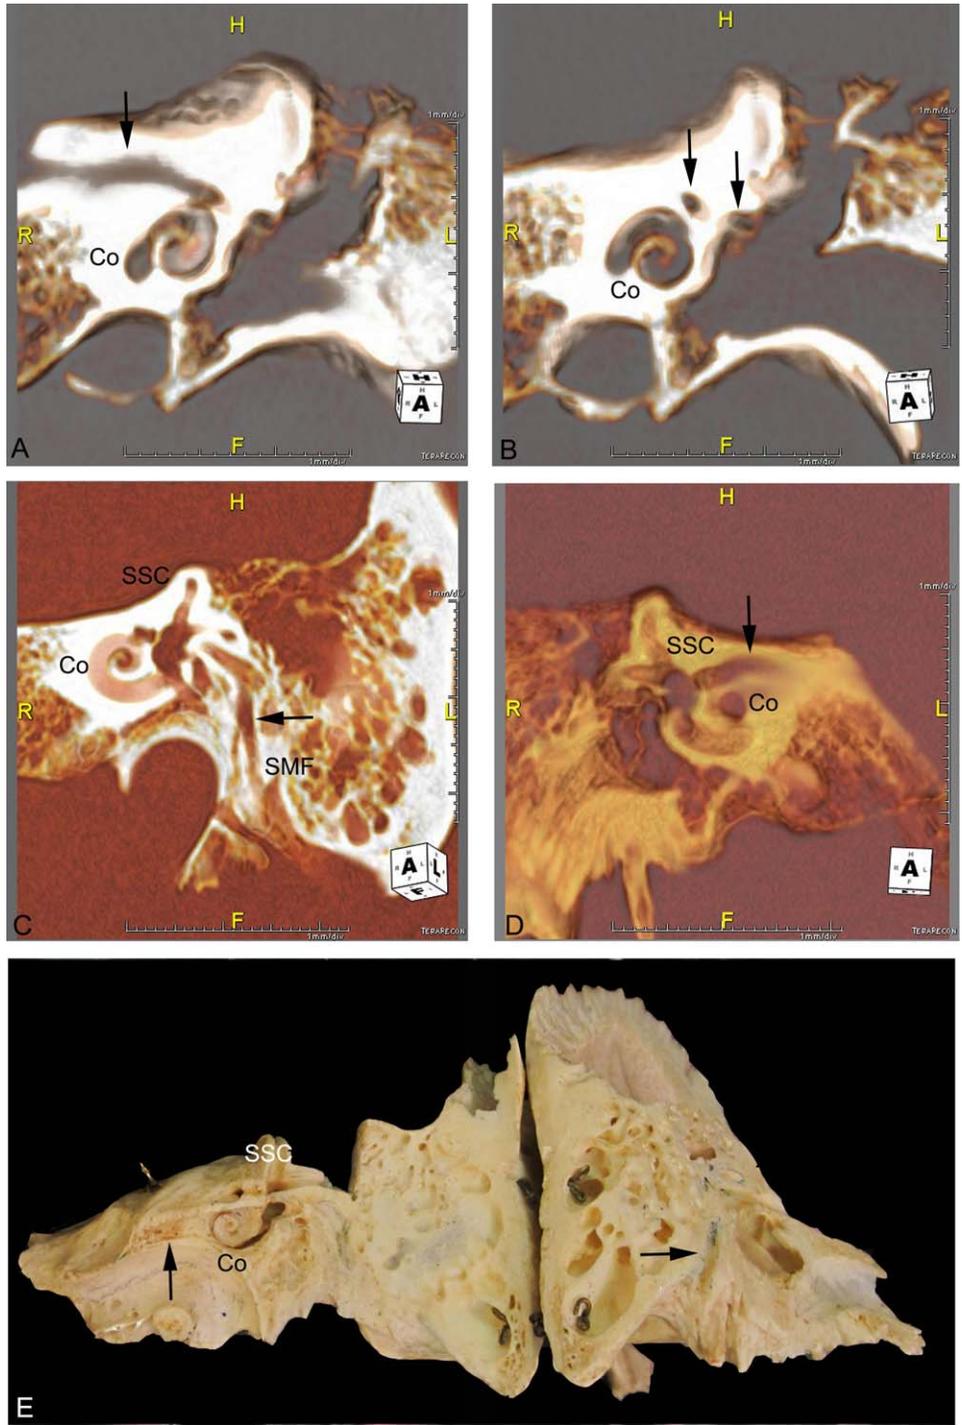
(A–D): 3D-CT reconstruction of a skull showing the three segments of the facial canal (a. labyrinthine, b. tympanic, c. mastoid). e. picture of an open tympanic pyramid. Co, cochlea, SSC superior semicircular canal, SMF, stylomastoid foramen. Arrows pointed the facial canal. CT images were obtained on a 256-slice multidetector CT scanner (Philips iCT 256; Philips Medical
